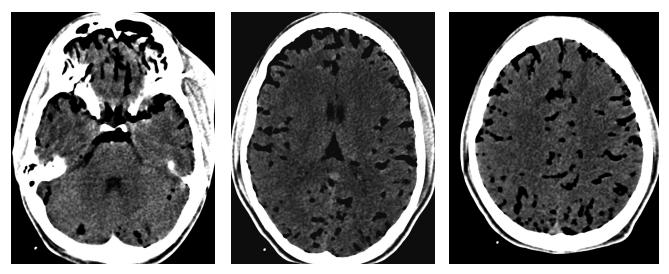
Selected axial CT images demonstrating diffuse pneumocephaly from the skull base to the apex.
